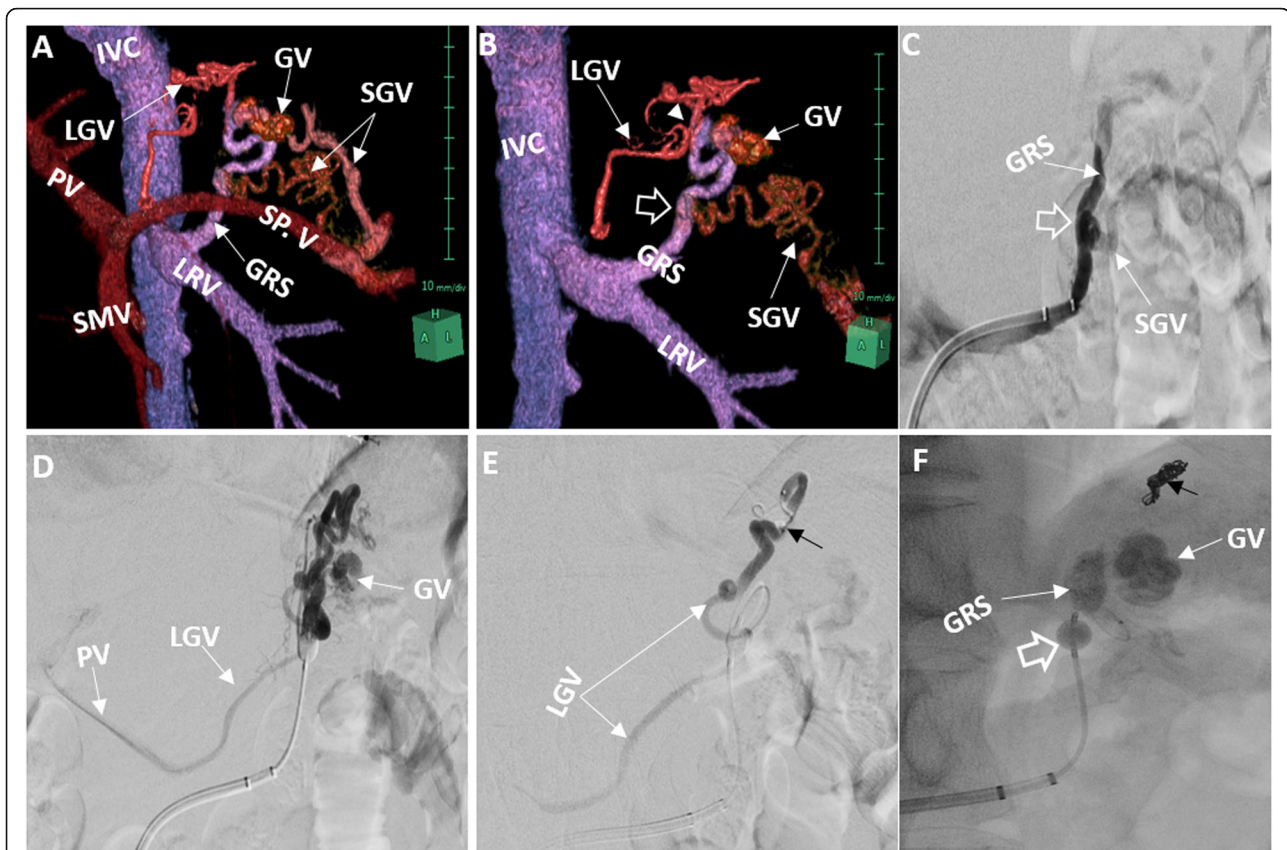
Selective BRTO technique. a Oblique volume rendering (VR) image obtained from pre-BRTO CE-CT portal phase images shows gastric varices (GV) supplied from short gastric vein (SGV) and drained by gastroduodenal shunt (GRS). b The same oblique VR image in a but after subtraction of the feeding SGV, splenic vein (Sp.V), and portal vein (PV) to clearly visualize the direct connection between the other SGV and the proximal part of GRS (hollow white arrow) and the direct connection between left gastric vein (LGV) and the distal part of GRS very near to GV (arrowhead). c DSA image during retrograde venography of the GRS shows the connection between SGV and the proximal GRS (hollow white arrow). d DSA during balloon occluded retrograde venography of GRS shows partial visualization of GV with contrast reflux through the direct connection of LGV with the distal GRS (EAEDC) toward portal vein (PV). e Selective venography within the LGV EAEDC after successful catheterization of the EAEDC using microcatheter (black arrow) for EAEDC coiling to prevent EOI reflux into the PV. f Fluoroscopic image at the end of BRTO shows balloon catheter (hollow white arrow) positioned at the middle part of the GRS above the level of SGV EAEDC while LGV EAEDC was coiled (black arrow) with total opacification of the distal part of GRS and GV with EOI
